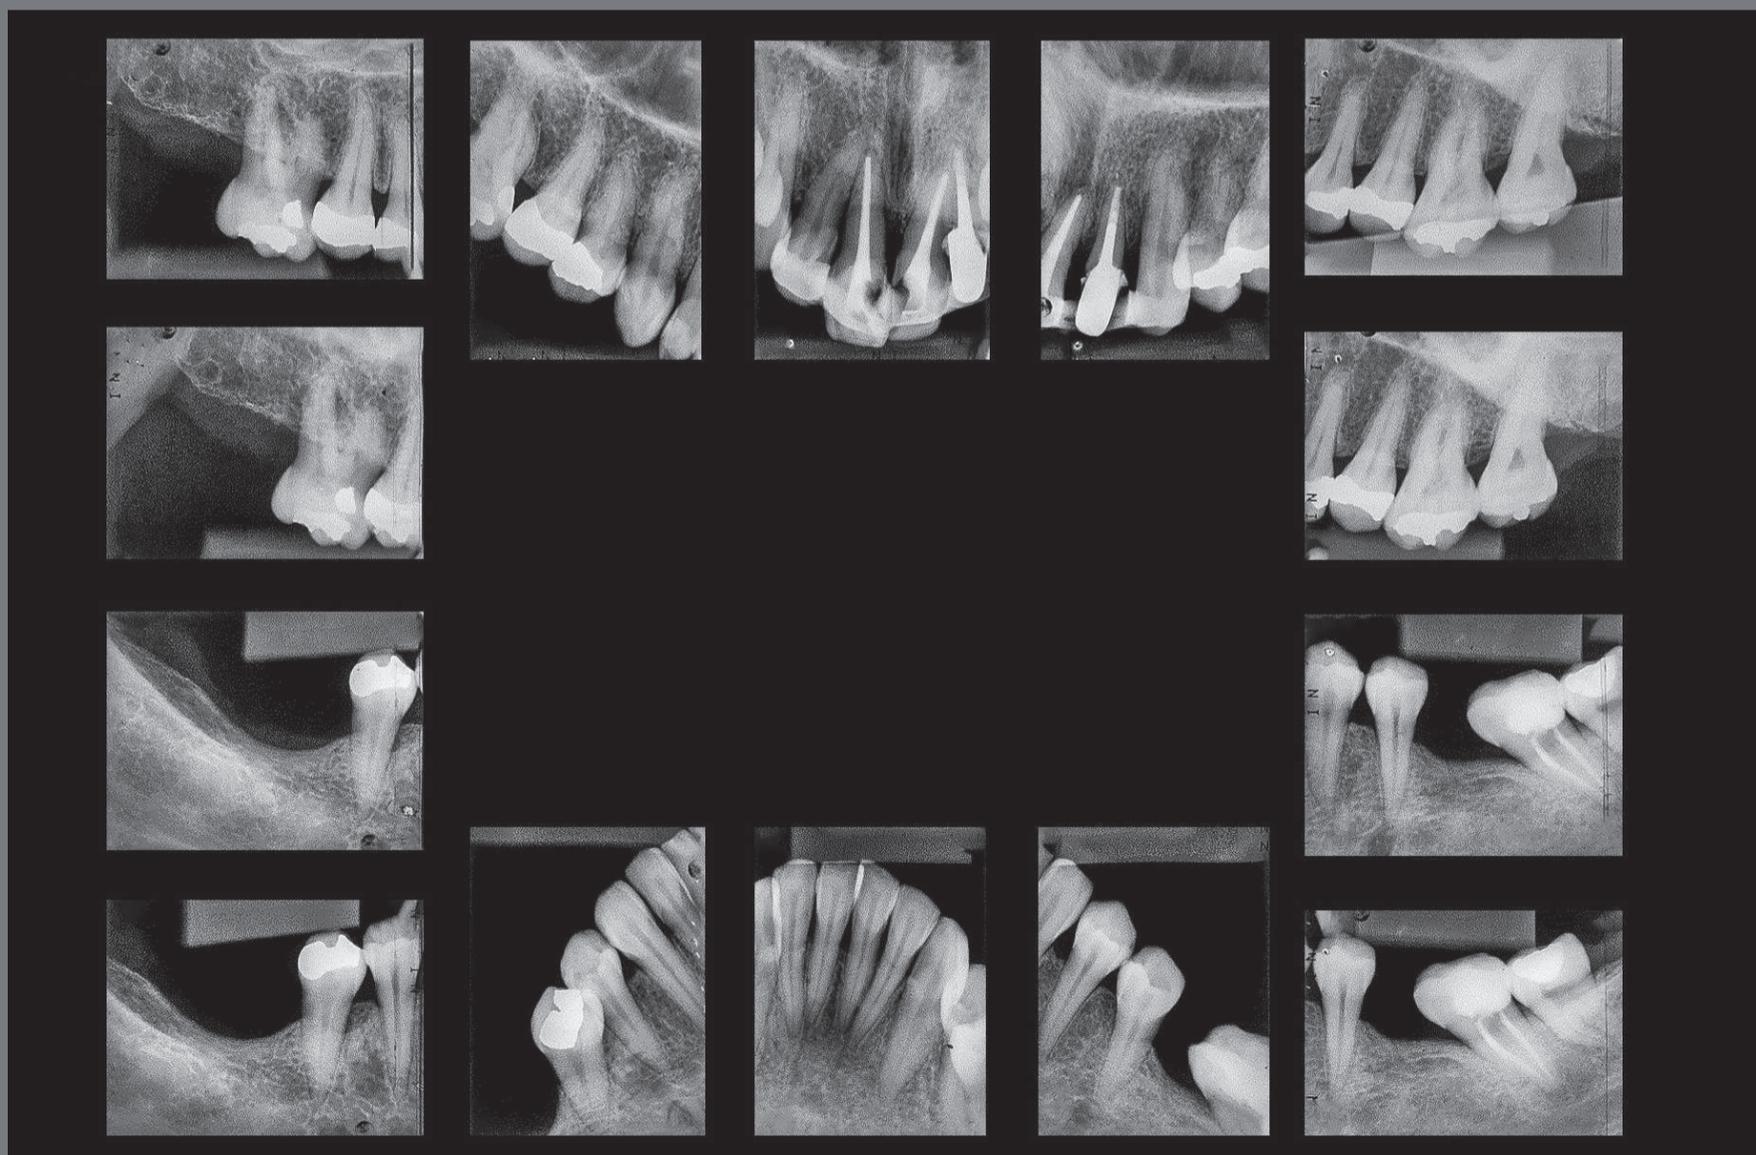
Initial periapical radiographs.
